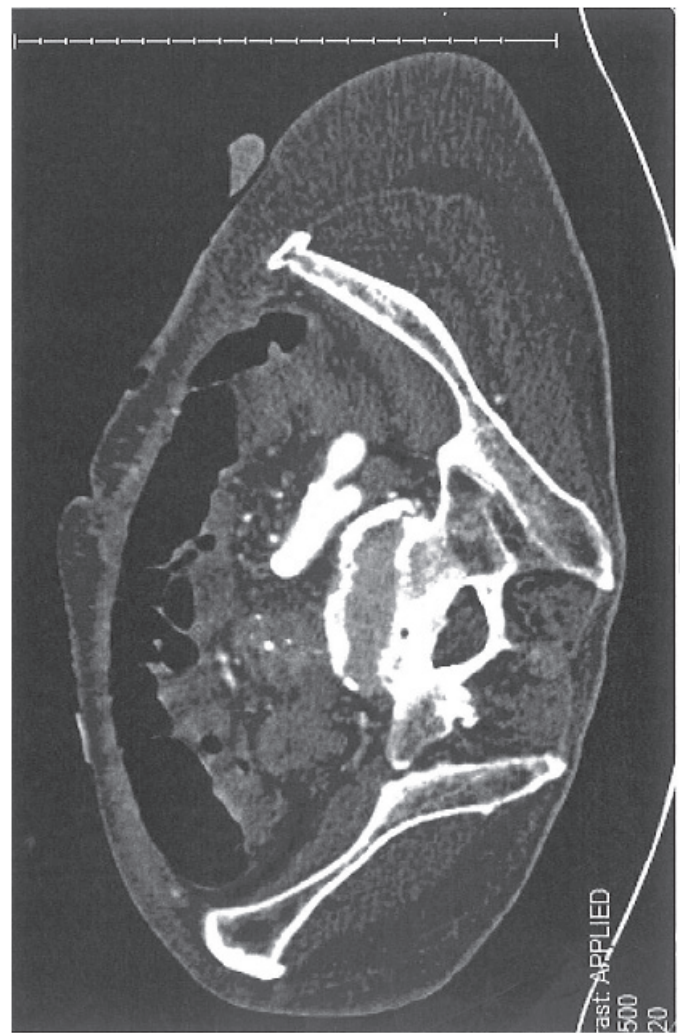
Computed tomography imaging of ilio-sigmoid colonic fistula.
